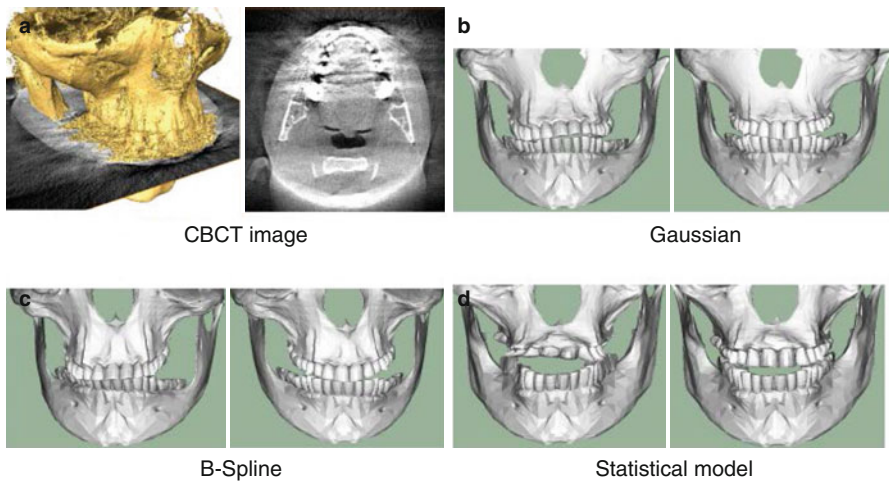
Registration of skulls from CBCT data: (a) shows a slice through the image and a reconstruction of the surface obtained using threshold segmentation. (b–d) show registration results obtained using different deformation models. The left images show a normal registration, while in the right images a spatially-varying registration has been used, showing the ability of the method to deal with metal artefacts
